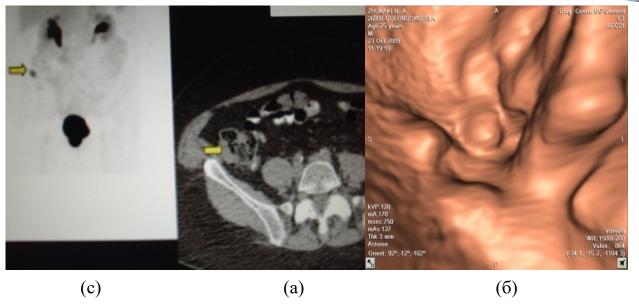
MSCT(a), spiral tomography (b) and PET/CT of the cecum tumor (c).
